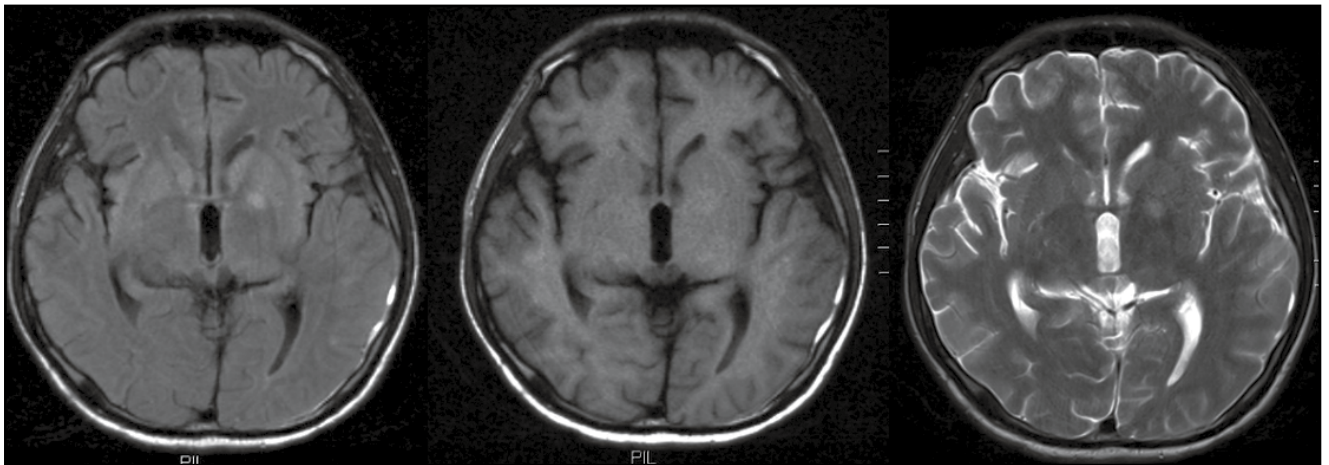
Head MRI on August 25, 2011. Patchy abnormal signals were seen in the left basal ganglia. T1WI showed intermediate signal intensity, T2WI showed high signal intensity, water- and fat-suppressed imaging showed high signal intensity. This suggested left basal ganglia lesions and left temporal subdural hematoma.
